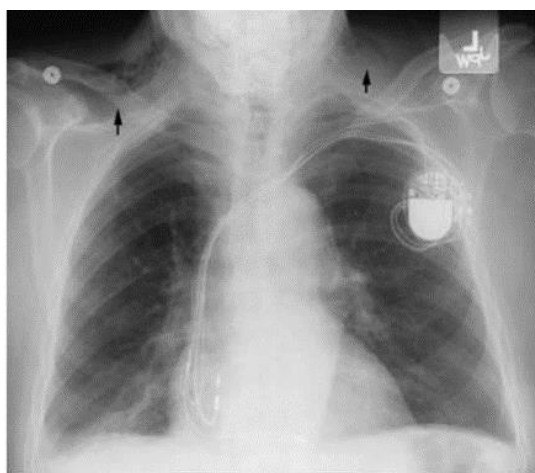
X-ray image of the thorax after flexible endoscopic surgery on Zenker's diverticulum showing subcutaneous emphysema in the cervix.³
